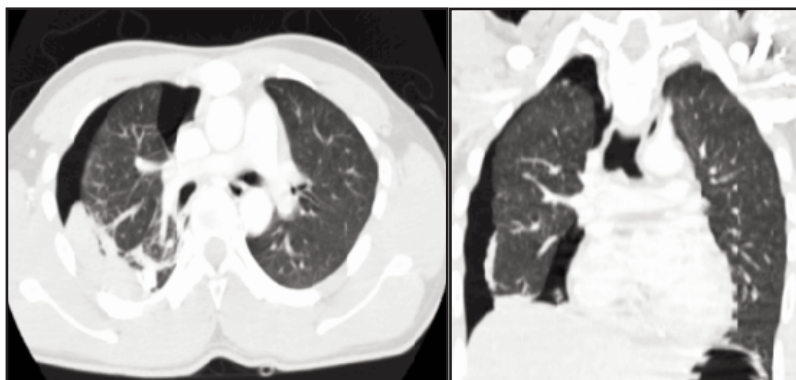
(Case 1) : CT thorax shows evidence of right pneumohemothorax.
